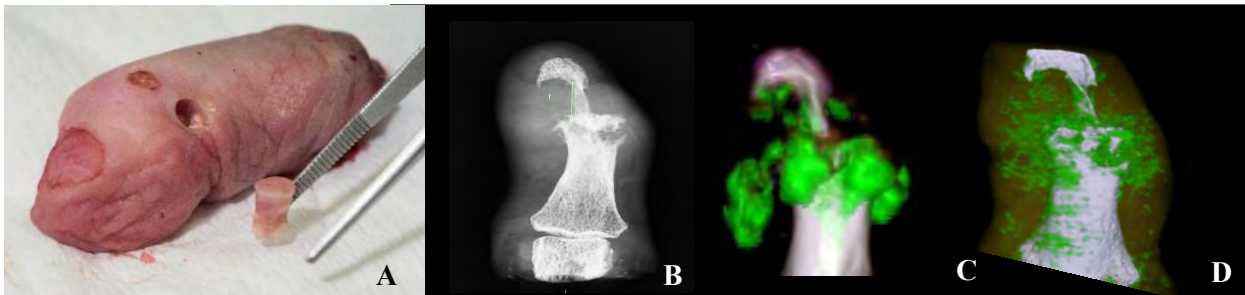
(A) Photo of the finger with a gouty tophus, (B) Plain X-ray image, (C) DECT image, (D) SPCCT image.
